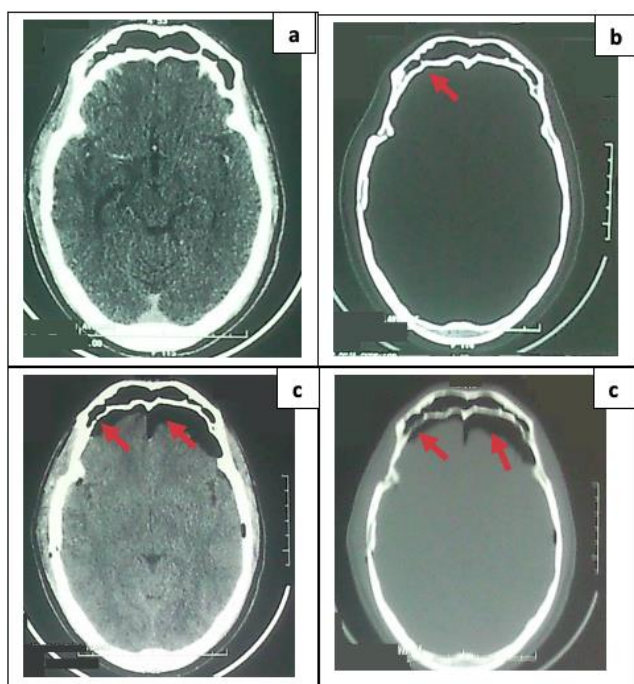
CT scan images of a non-operated patient who initially had a discrete fracture of right frontal sinus posterior wall (right fronto-temporal fracture) that progressed to compressive bifrontal pneumocephaly revealed by significant psychological disorders that persisted despite cranialization and obliteration of the right frontal sinus. Initial axial parenchymal (a) and bony window (b) showing a discrete right frontal sinus posterior wall fracture. Control images in axial section parenchymal (c) and bone window (d) showing a significant compressive bifrontal pneumocephaly complicating the initial right frontal sinus posterior wall fracture.
